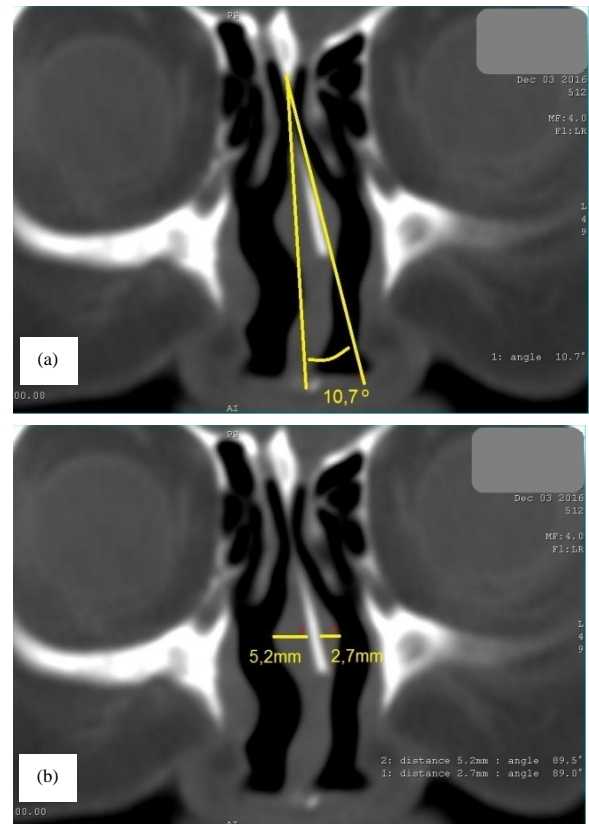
(a-b): (a) Measurement of nasal septum deviation degree and (b) Analysis of contralateral and ipsilateral septal body in paranasal sinuses CT scan of coronal plane
